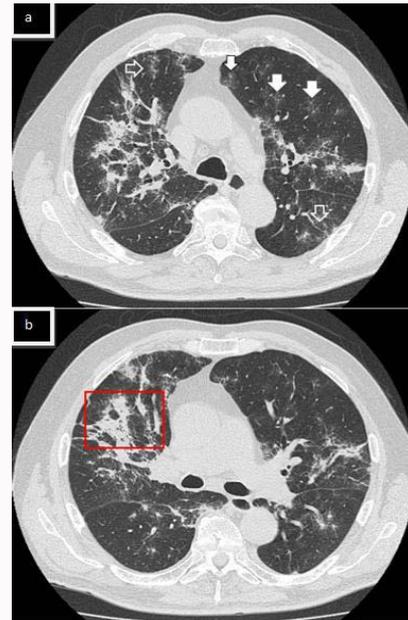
Chest CT: bilateral and multifocal interlobular septal thickening (empty arrows in a) together with small ground glass opacities (white arrows in a) and a discrete consolidative opacity (red box in b). CT: Computed Tomography
